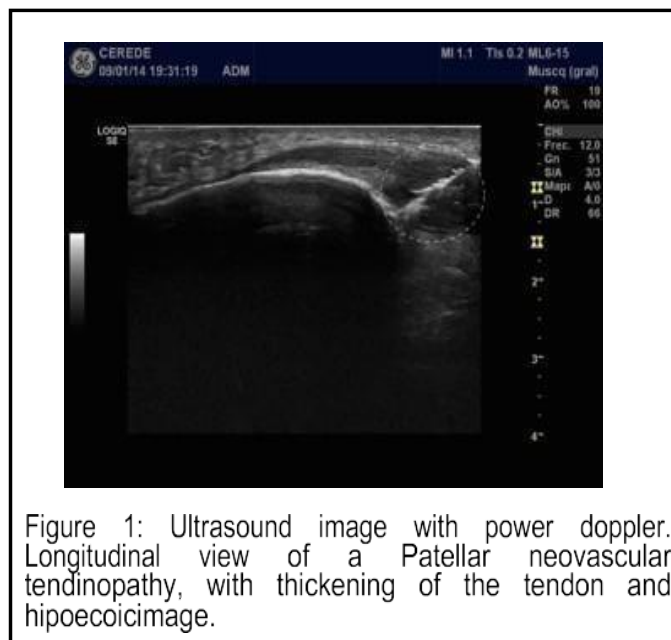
Ultrasound image with power doppler. Longitudinal view of a Patellar neovascular tendinopathy, with thickening of the tendon and hypoechoic image.
